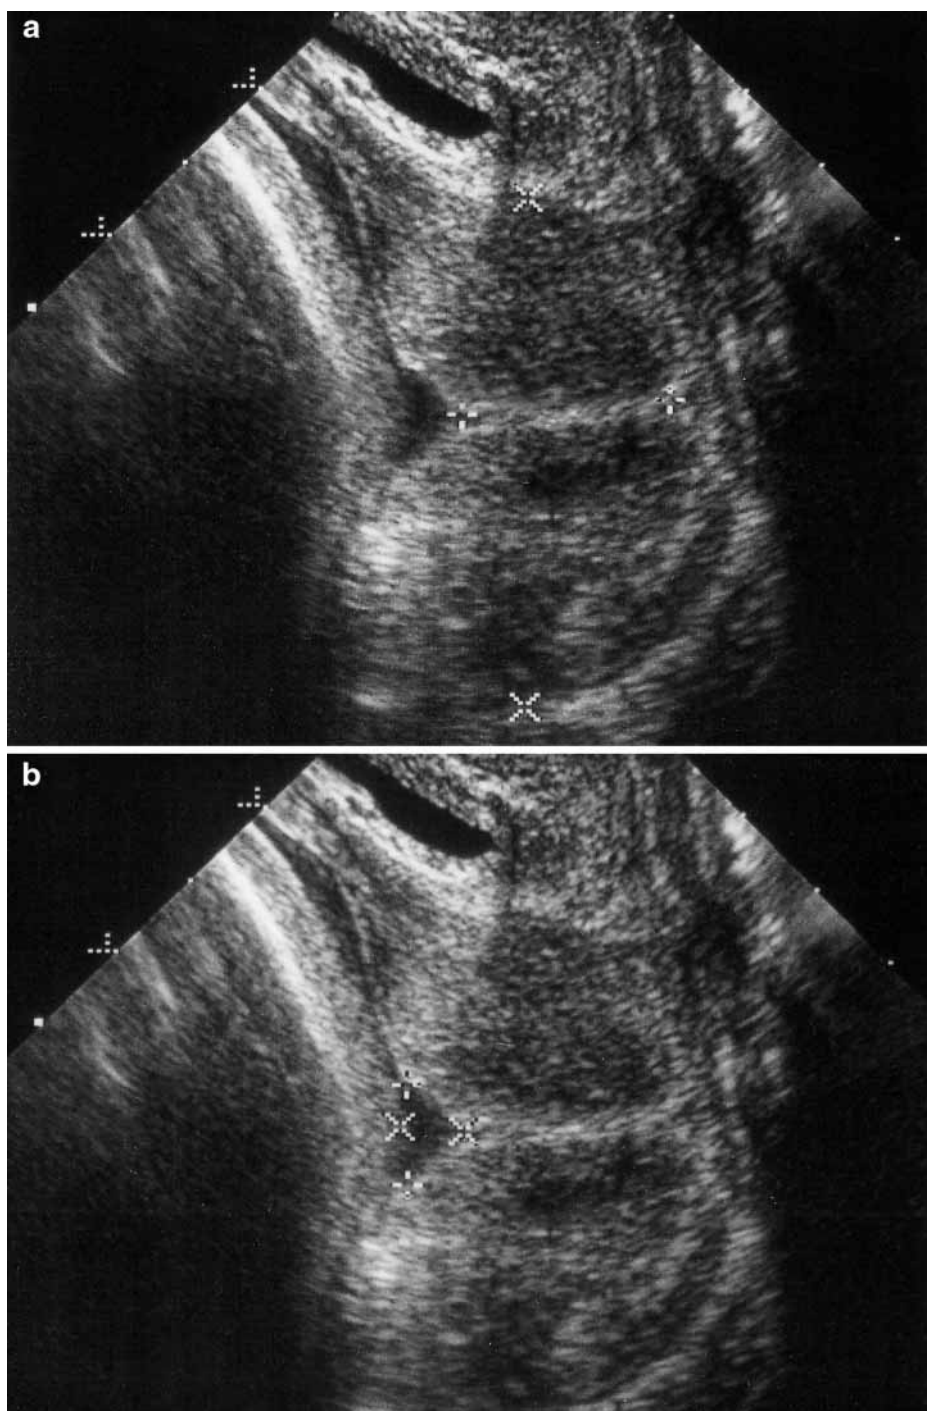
(a) Ultrasound image showing measurement of cervical length and width. For measurement of cervical length, the calipers are placed at the inner and outer cervical os. The measurement includes only that part of the cervical canal that is bordered by endocervical mucosa (4). The measurement of cervical width is taken at the midpoint between the inner and outer cervical os and perpendicular to the longitudinal axis of the cervical canal (4, 10, 11, 13–15). (b) Ultrasound image showing a measurement of a V-shaped inner cervical os. The apex of the V borders the endocervical canal.
